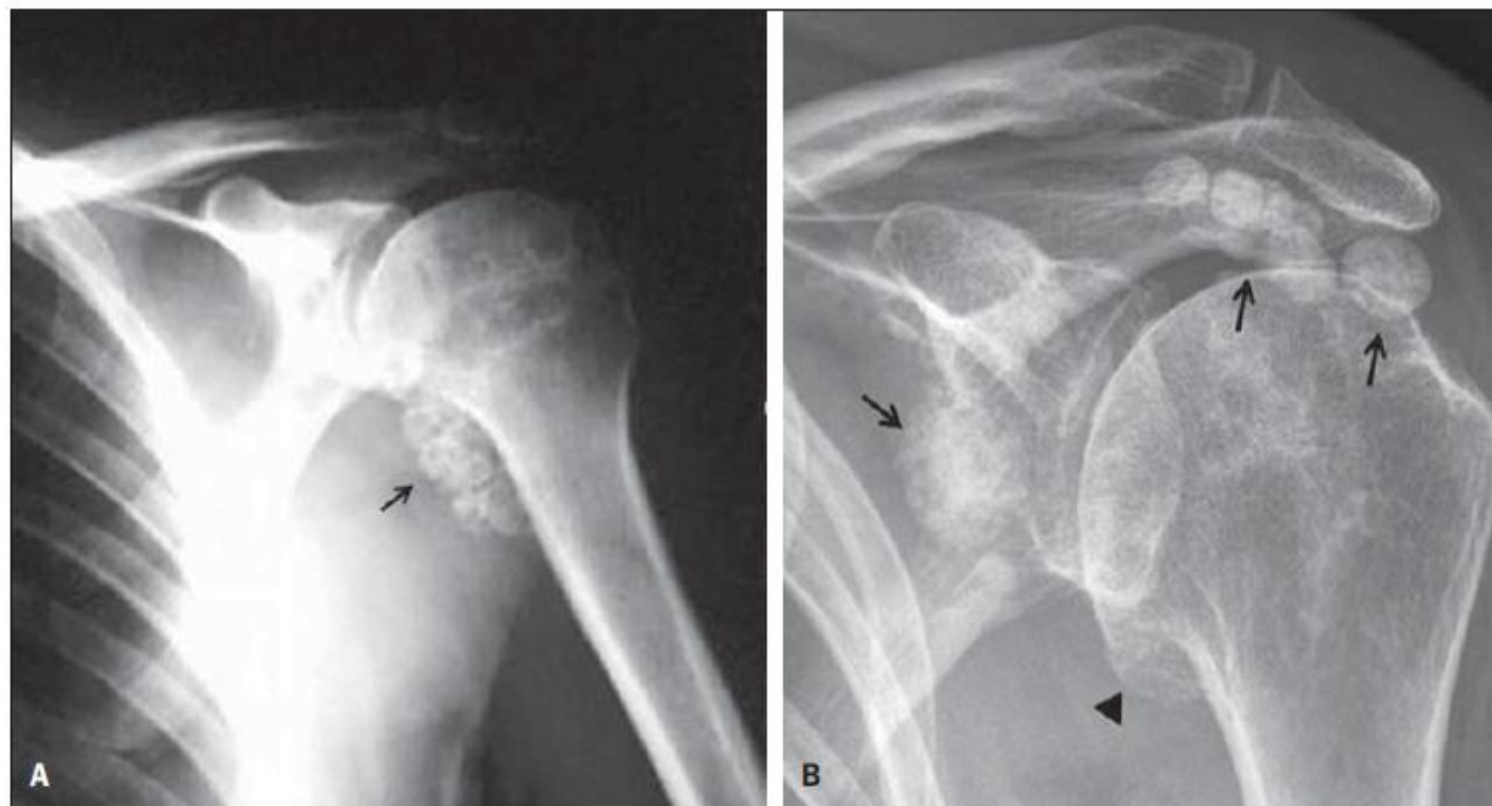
A: *Primary synovial osteochondromatosis.* Radiography, anteroposterior view of the shoulder demonstrating multiple, typical, ring-shaped calcifications similar in size and shape, located at the level of the axillary recess of the glenohumeral joint (arrow). B: *Secondary synovial osteochondromatosis.* Radiography, anteroposterior view of the shoulder demonstrating osteodegenerative changes characterized by the presence of osteophytes in the inferior articular margin of the humeral head (arrowhead) and presence of multiple juxtarticular rounded-shaped calcifications with varied sizes (arrows).
